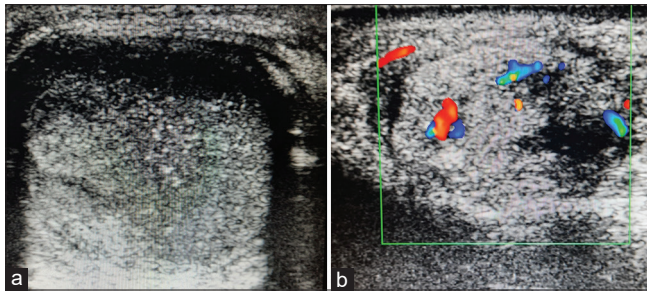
(a) High-resolution ultrasonographic image of the testis showing multiple patchy hypoechoic areas within the testicular parenchyma consistent with testicular contusions. (b) High-resolution ultrasonographic image at the level of the internal ring of the inguinal canal demonstrating a hyperechoic area extending from the internal inguinal orifice to the upper pole of the testis
